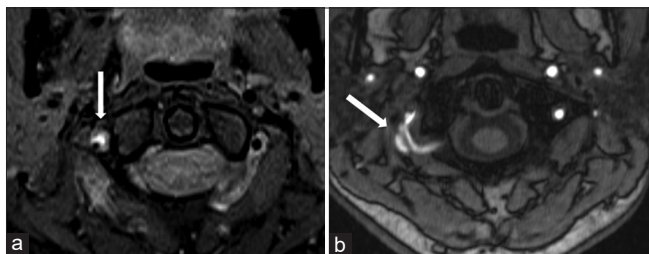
Right vertebral artery dissection. MRI of a 50-year-old hypertensive male with the complaints of acute giddiness and slurring of speech shows crescent-shaped hyperintense hematoma on axial T1fs image around the anterior aspect of the narrowed right vertebral artery (arrow in a) and a thick dissection flap on axial 3D TOF image (arrow in b).
